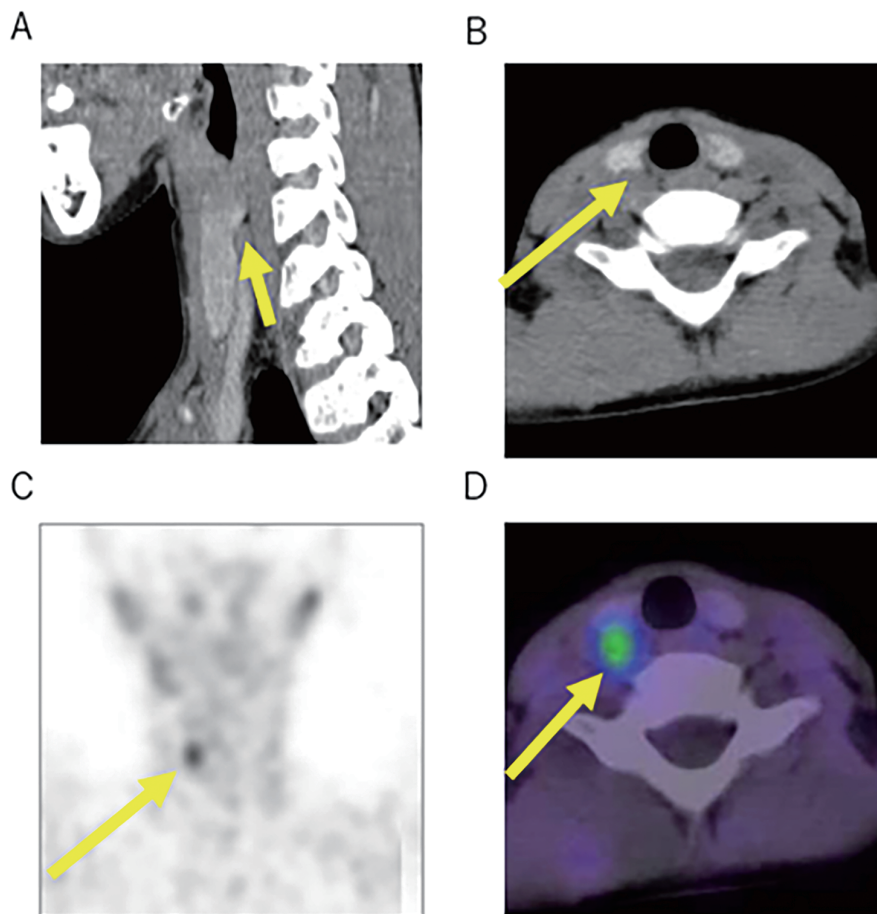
Radiological findings. Contrast computed tomography (A, B) and Tc-99m sestamibi scintigraphy (C, D). Arrows indicate an enlarged right superior parathyroid gland.
